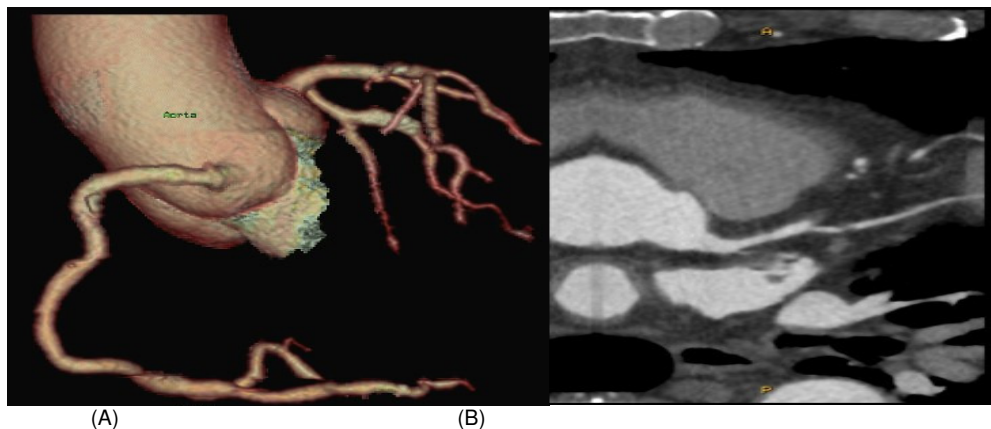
Shows Coronary CT angiography of (A) 3D volume rendering image, and (B) curved multiplanar reformatted, (MPR) of stent in the marginal artery. CAC score is 181. In the middle part of the LAD showed non-calcified atheromatous plaque with stenosis, mixed type of plaque with significant stenosis in the 1st diagonal. Eccentric calcified plaque with moderate stenosis in the 2nd diagonal.
